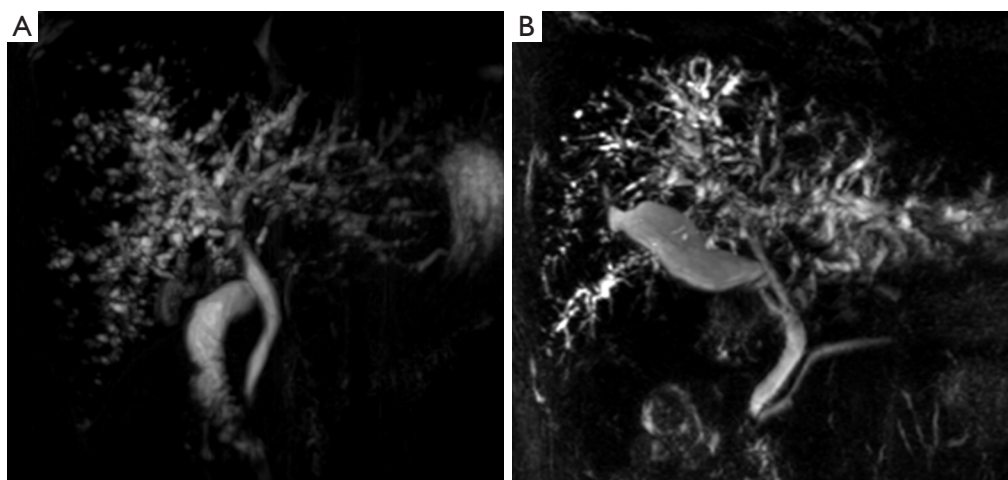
MRI imaging of ischemic cholangiopathy patients. (A) Showed innumerable irregular small cystic lesions along the entire IHD and dilated IHD with multifocal stricture including the hilar portion without demonstrable mass lesion; (B) showed multifocal irregular beaded appearance and wall thickening of the IHD. There were not definitely visualized stones in IHD or CBD. MRI, magnetic resonance imaging; IHD, intrahepatic duct; CBD, common bile duct.
